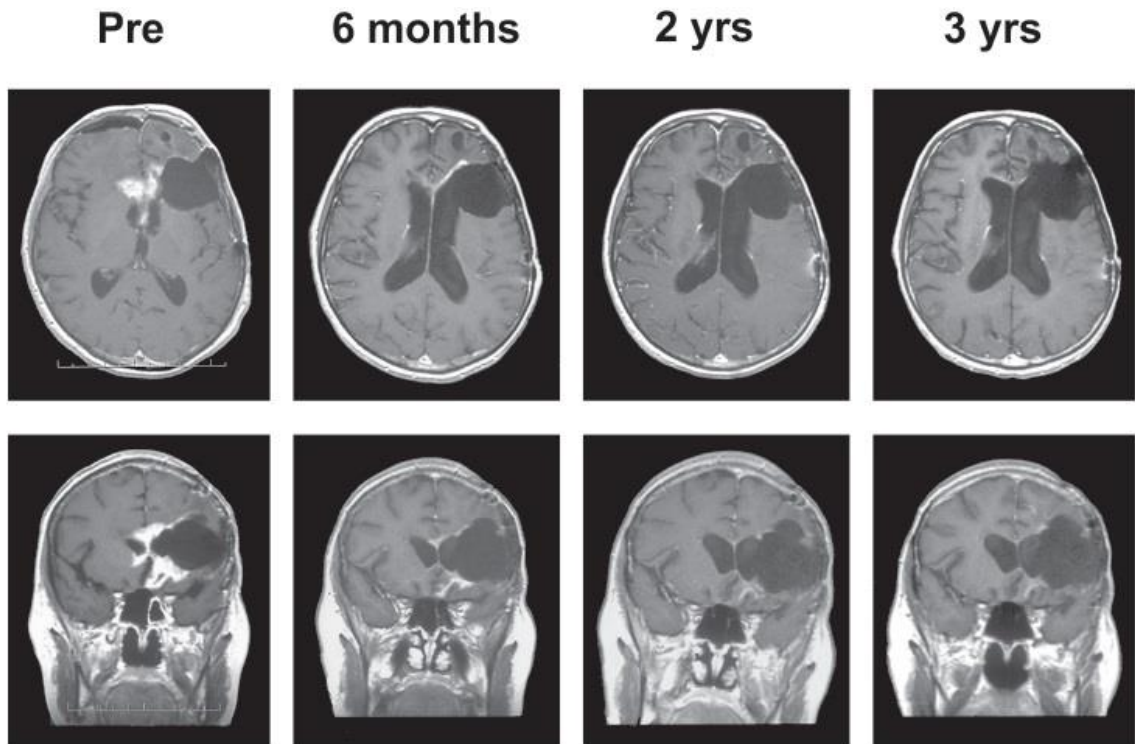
Contrast-enhanced axial (top panels) and coronal (bottom panels) MRI images showing extent of tumor prior to treatment and at six months, two years, and three years after TP-38 treatment.
